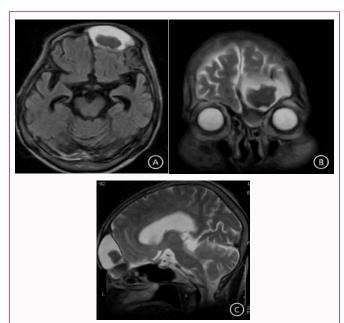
Axial T1-weighted (A) and coronal T2-weighted (B) magnetic resonance imaging scans shows expansile, none homogenous frontal sinus mass. Sagittal T2-weighted (C) magnetic resonance imaging scan shows expanded frontal sinus mass and frontal recess mass seemed to be divided into two layers.
